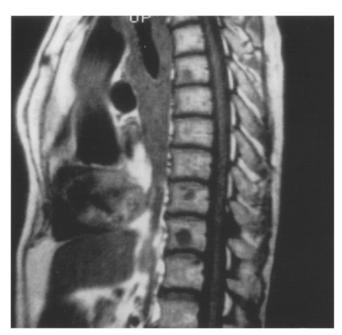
MRI: low signals suggestive of spinal metastases (BS was negative in this patient)
